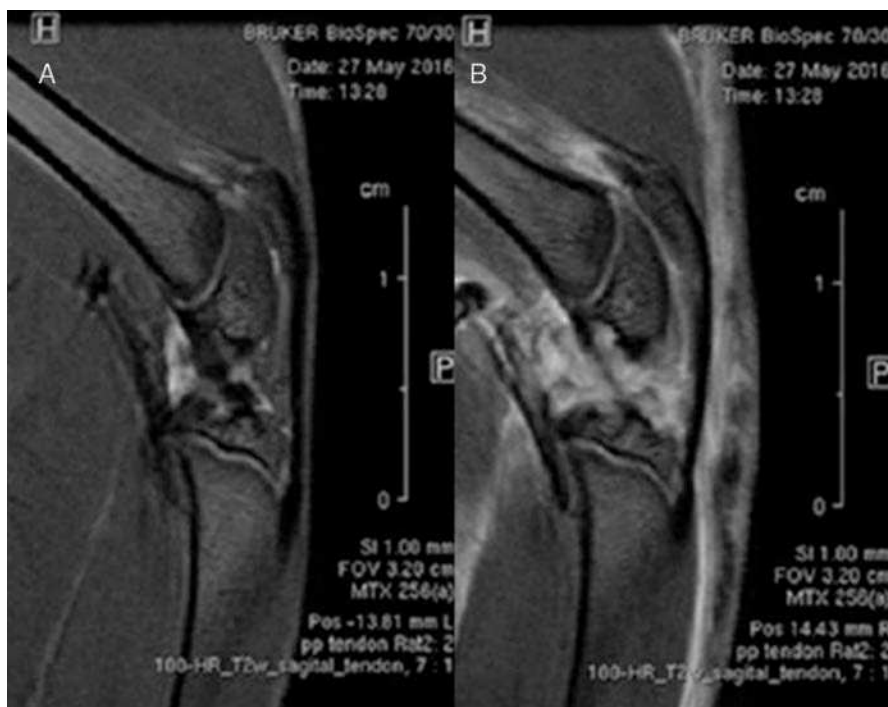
Comparative study using magnetic resonance imaging. No differences were found in the structure of the healthy patellar tendon (A) and in the injured tendon (B).
